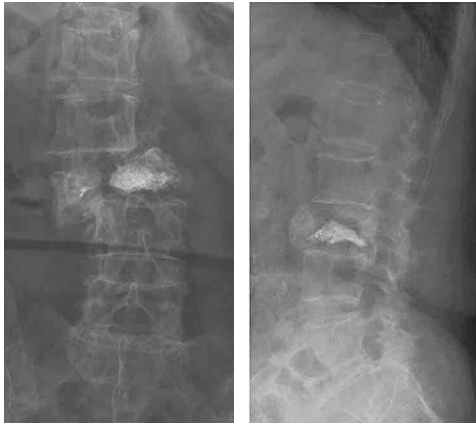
Plain radiographs revealing a fracture-dislocation of L3 and PMMA cement in the vertebral body.
